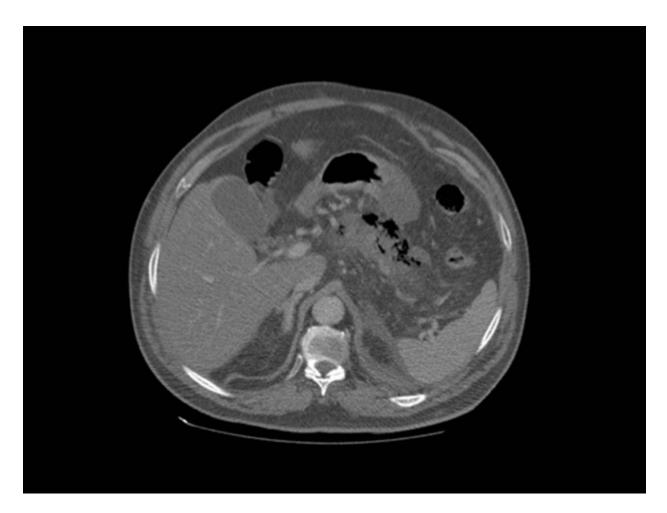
Emphysematous pancreatitis. CT scan of the abdomen demonstrates gas surrounding the body and tail of the pancreas. There are inflammatory changes involving the surrounding fat of the pancreas.
